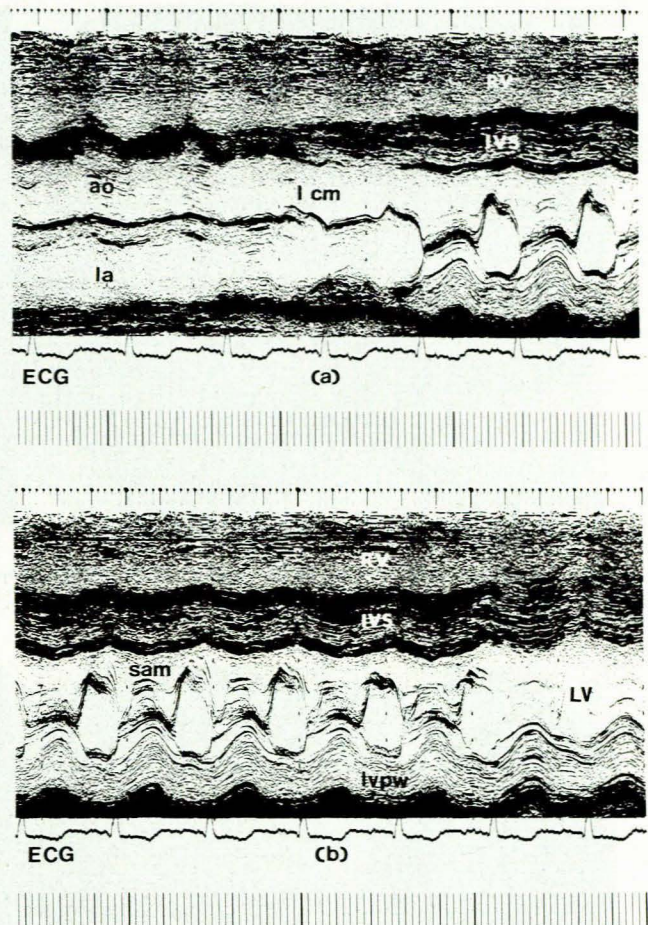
M-mode echocardiograms: (a) asymmetrical septal hypertrophy is present, there is no left atrial enlargement; (b) marked systolic anterior motion (SAM) of the anterior leaflet of the mitral valve is demonstrated. Asymmetrical septal hypertrophy is again seen (ao = aorta; la = left atrium; RV = right ventricle; lvpw = left ventricular posterior wall).
